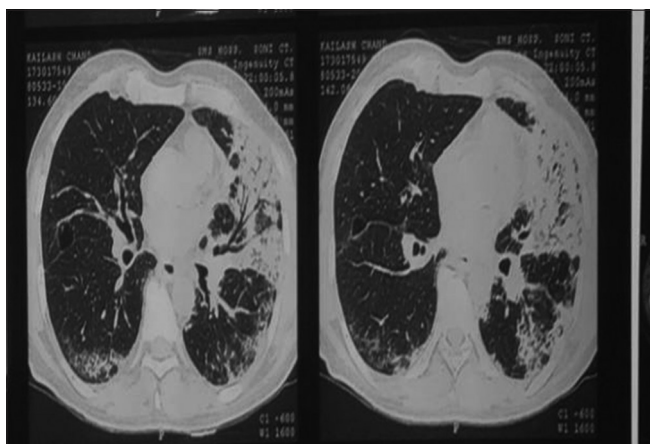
High-resolution computed tomography chest revealed consolidation in middle and lower zone of the left lung with ground-glass opacity with centrilobular nodules
